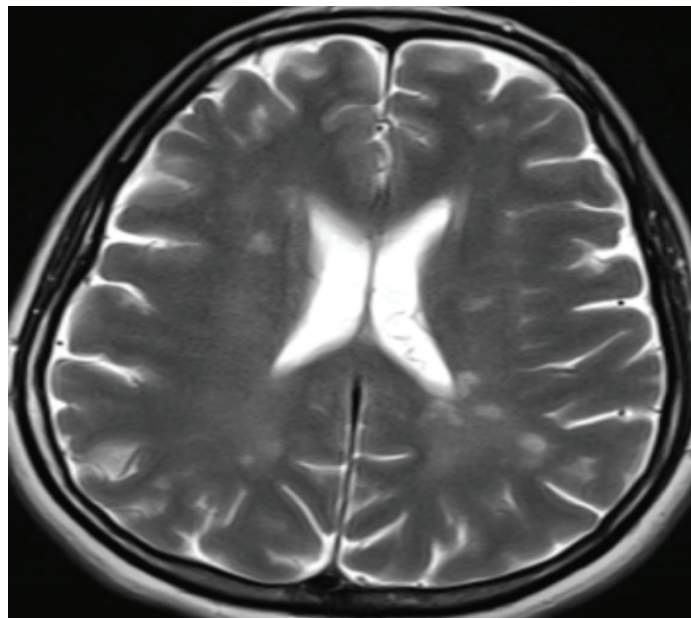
Brain magnetic resonance imaging of the patient. Multiple demyelinating plaques on axial T2-weighted image
